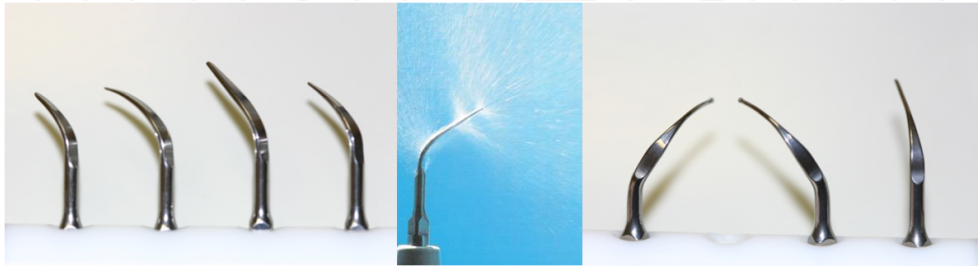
Supra (left) and thin subgingival (right) ultrasonic tips should always work with abundant irrigation
